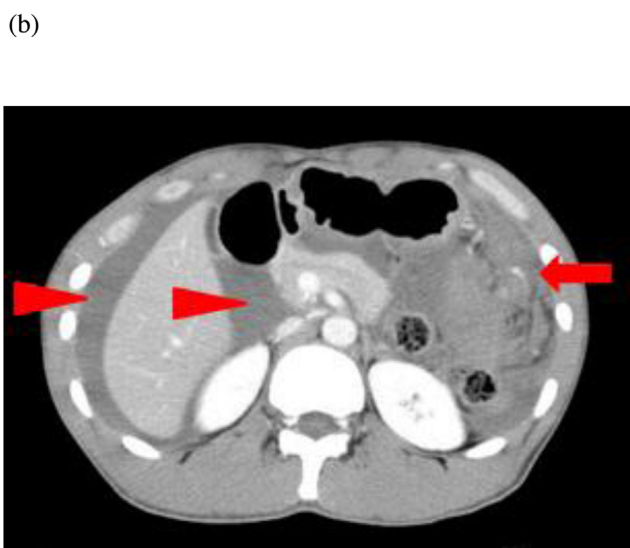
ab. Preoperative enhanced abdominal computed tomography scan. A diffuse intraperitoneal fluid collection is shown (arrowhead). Extravasation near the stomach is in the left upper quadrant (arrow).
